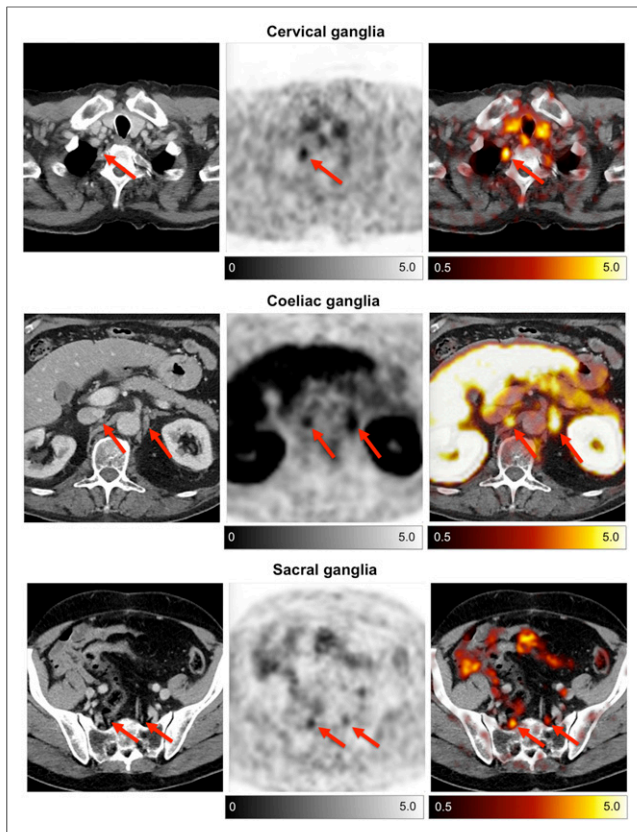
^{68}Ga -PSMA-HBED-CC uptake of cervical, celiac, and sacral ganglia. (Left) Diagnostic, contrast-enhanced CT. (Middle) ^{68}Ga -PSMA-HBED-CC PET. (Right) Overlay of ^{68}Ga -PSMA-HBED-CC PET and CT. Red arrows indicate ganglia at respective location.
